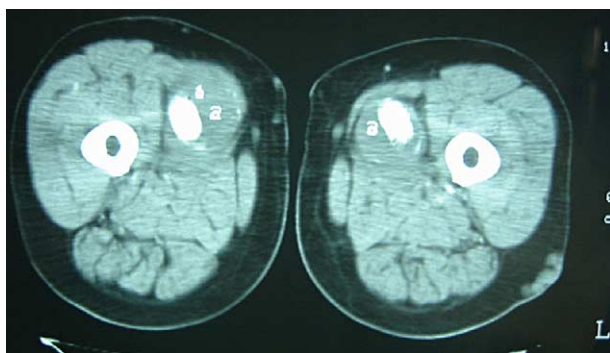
Follow-up CT scan, 6 months after the procedure demonstrates intact stent grafts with no endoleak or migration in addition to 0.7 cm aneurysm shrinkage in the right and 0.4 cm in the left aneurysm.
